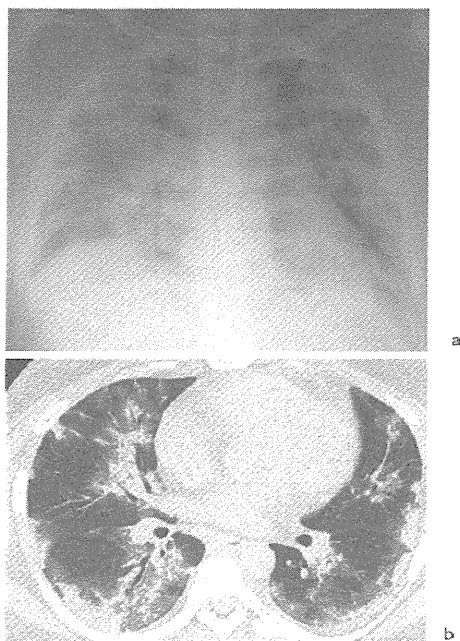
(a) Chest X-ray on admission showed bilateral diffuse infiltration. (b) Chest CT showed diffuse panlobular ground glass opacity (GGO) and consolidation, along with the bronchovascular bundles.
